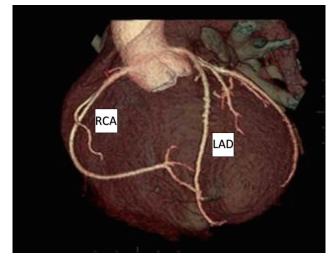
Comparison computed tomography (CT) angiogram of a pediatric heart without aneurysms. (RCA: right coronary artery; LAD: left anterior descending)
